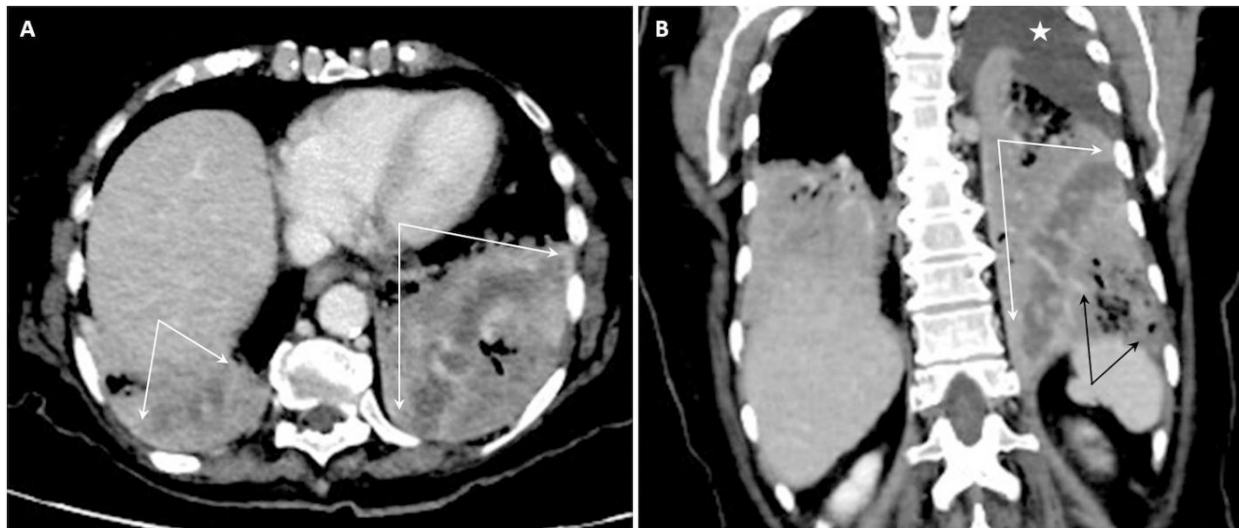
Contrast-enhanced chest computed tomography (CT) of a 76-year-old patient with *Legionella* and *Acinetobacter* pneumonia. Axial (A) and coronal reformat (B) demonstrate bilateral lower lobes airspace consolidations with air bronchogram and areas of decreased attenuation highly suspicious for early pulmonary necrosis (A and B, white arrows). A well-demarcated stripe-shaped decreased attenuation is seen in the left lower lobe (B, white arrows). The partially aerated low attenuation lung parenchyma in the left lower lobe (B, black arrows) demonstrated ground glass opacities (GGO) on the lung window (B, black arrow). Mediastinal lymphadenopathy and pleural effusions were also present (B, asterisk).
